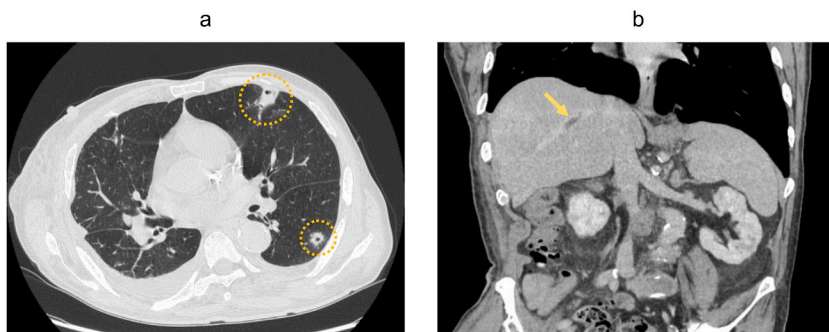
(a) Chest computed tomography detected multiple cavitated nodules (yellow circles). (b) Enhanced abdominal computed tomography showed thrombosis of the hepatic vein (yellow arrow).
